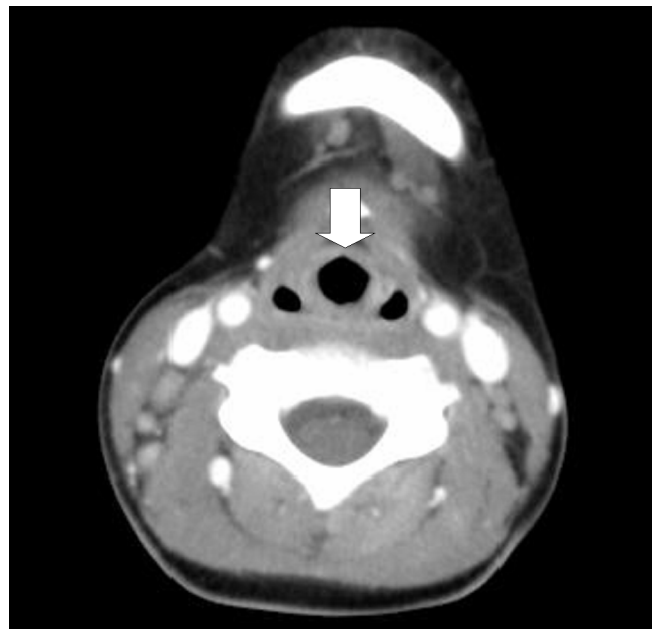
A repeat CT scan on eighth hospital day, showing decreased inflamed fluid collection, infiltrative change of retropharyngeal space, and swelling of parotid gland and tonsil in comparison to prior CT scan.
